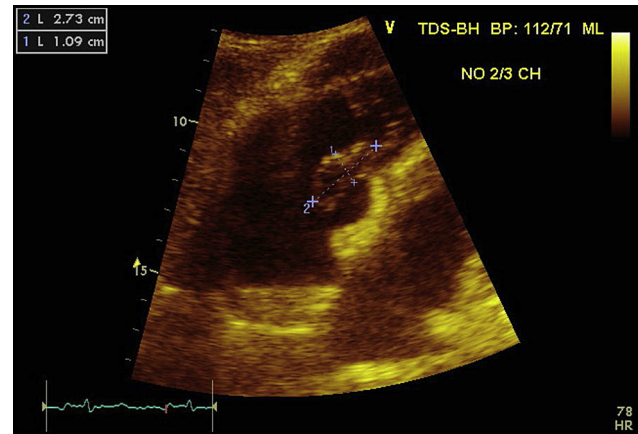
Transthoracic echocardiogram (TTE) showing large right atrial thrombus.
